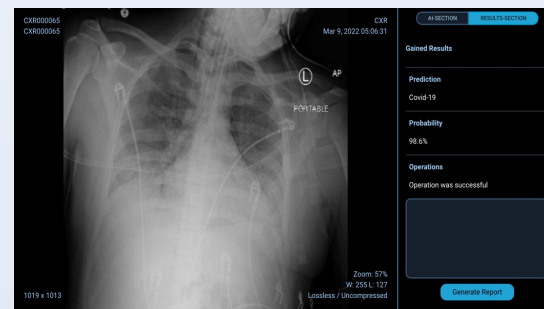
Chest x-ray show positive result for Covid-19 infection
